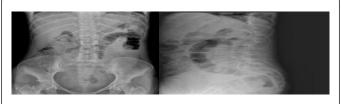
Plain AP A). and lateral B). radiographs of lumbar spine demonstrated a fracture at L1 with about 70% and 50% loss of height at anterior and middle column, respectively.
